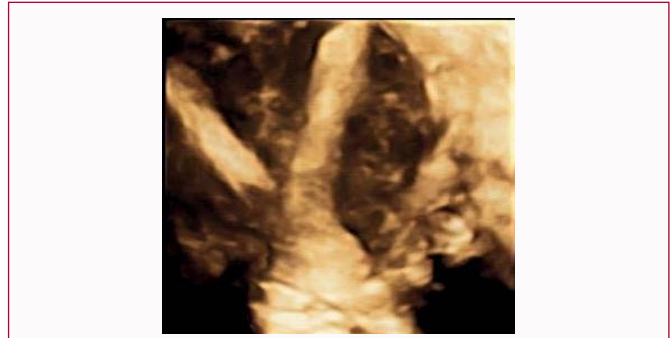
Three-dimensional transvaginal ultrasound image demonstrating septate uterus.
